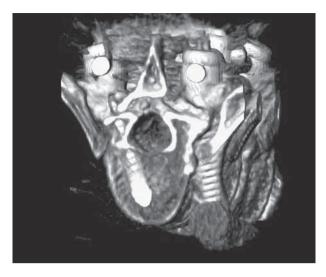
CT images of case 2 with contrast enhancement and 3D reconstruction showing more accurately the position of the screw and perforation of aorta.
